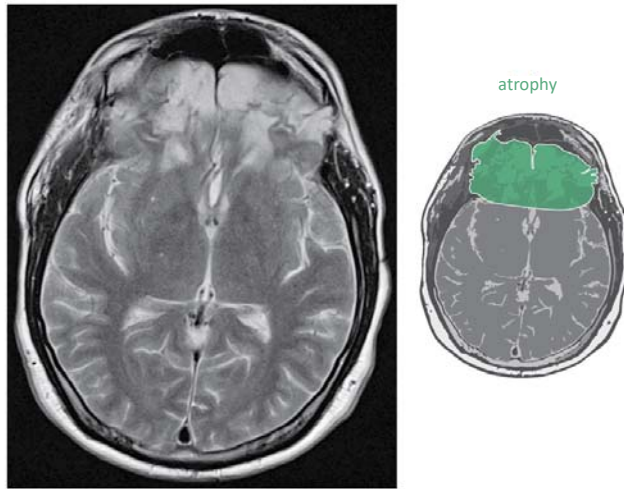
MRI-scan of the cerebrum of patient B (transversal coupe).
